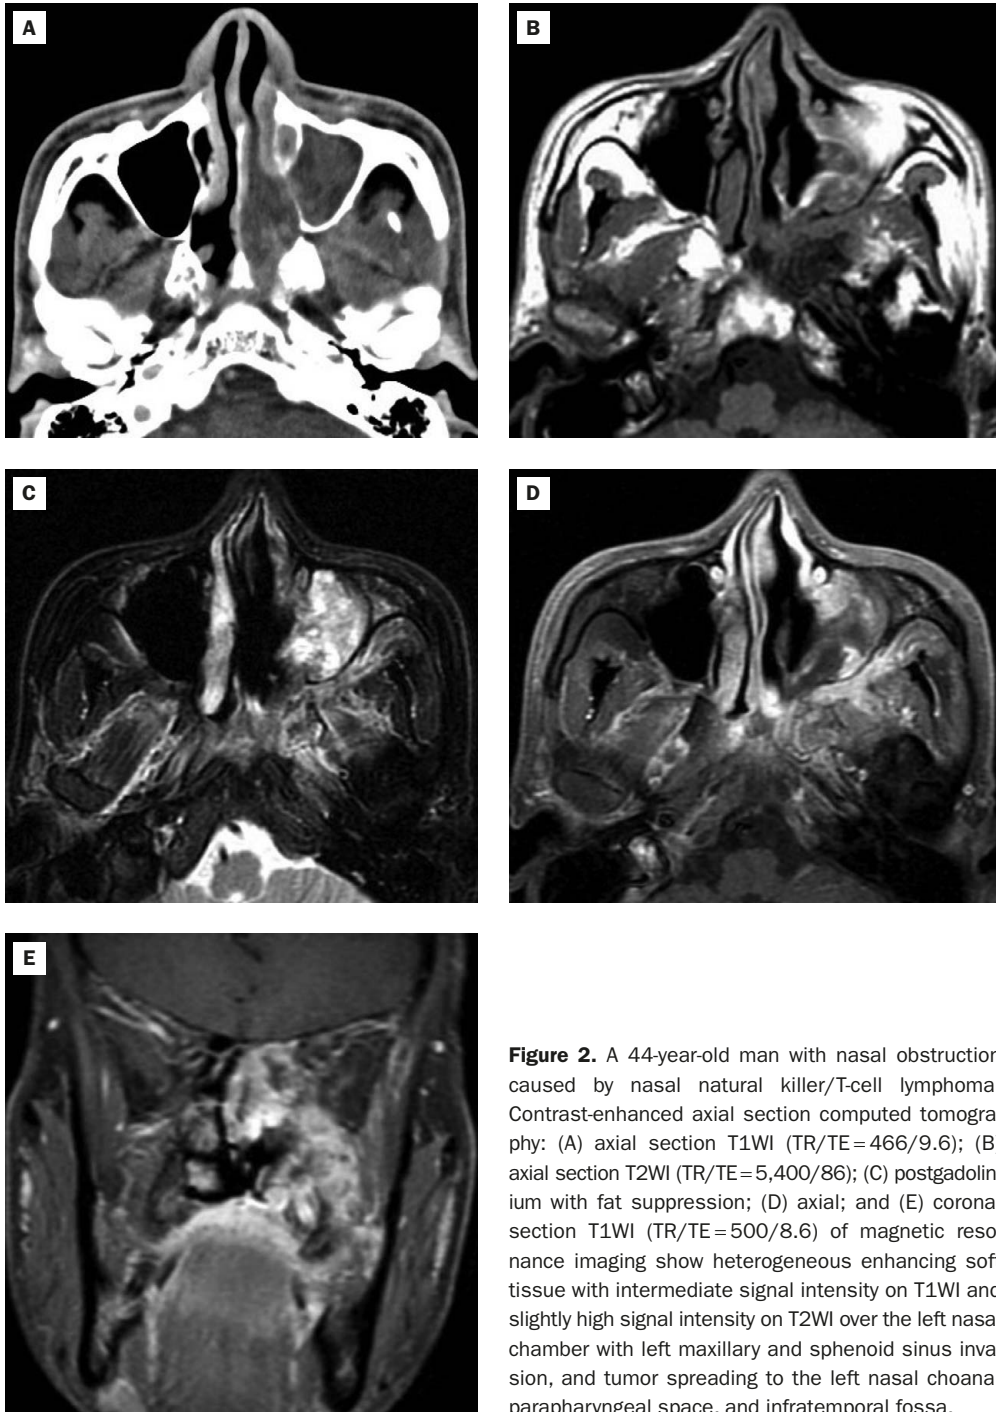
A 44-year-old man with nasal obstruction caused by nasal natural killer/T-cell lymphoma. Contrast-enhanced axial section computed tomography: (A) axial section T1WI (TR/TE=466/9.6); (B) axial section T2WI (TR/TE=5,400/86); (C) postgadolinium with fat suppression; (D) axial; and (E) coronal section T1WI (TR/TE=500/8.6) of magnetic resonance imaging show heterogeneous enhancing soft tissue with intermediate signal intensity on T1WI and slightly high signal intensity on T2WI over the left nasal chamber with left maxillary and sphenoid sinus invasion, and tumor spreading to the left nasal choana, parapharyngeal space, and infratemporal fossa.
